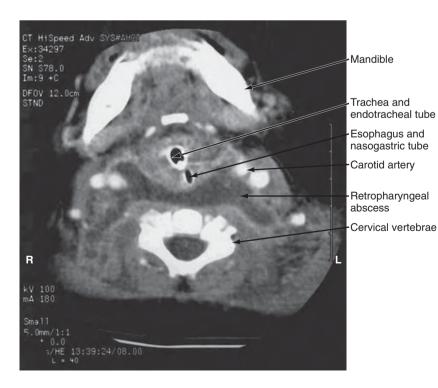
Computed tomography scan of a 6month-old child at the level of mandible demonstrating a retropharyngeal abscess. (From Cheema B, Grant CC, Mahadevan M, Beca J: An infant with a persistent empyema. Acta Paediatr 88:1168-1171, 1999.)
